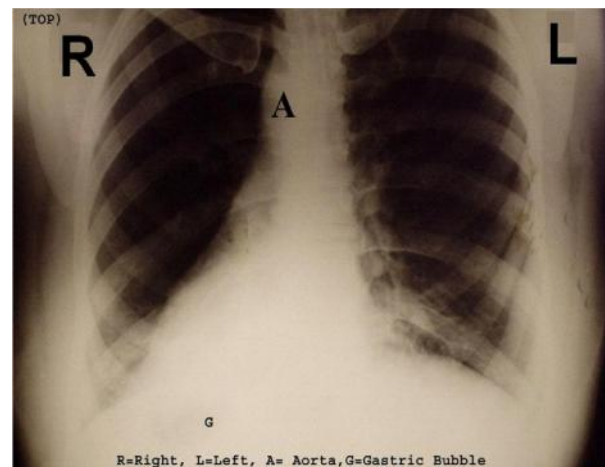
The chest radiograph of the patient showing dextrocardia and gastric air bubble on the right
